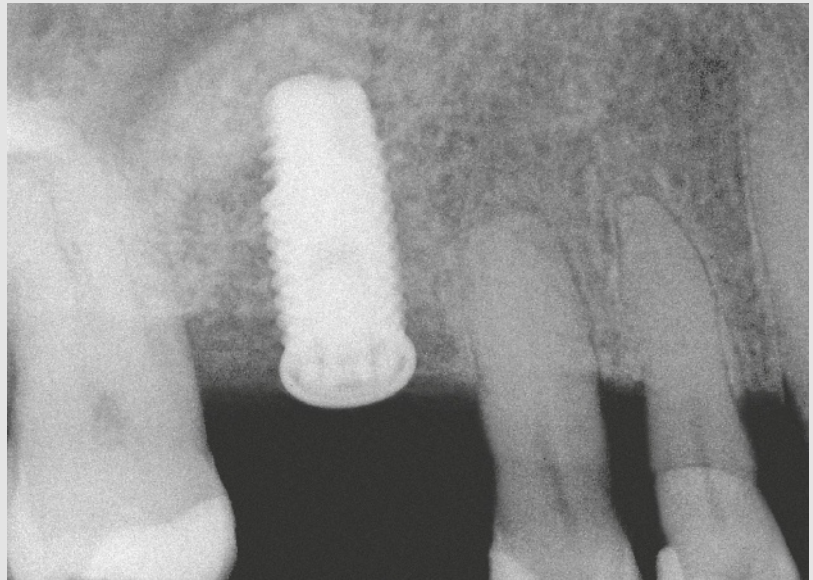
Immediate postoperative intraoral radiograph.
